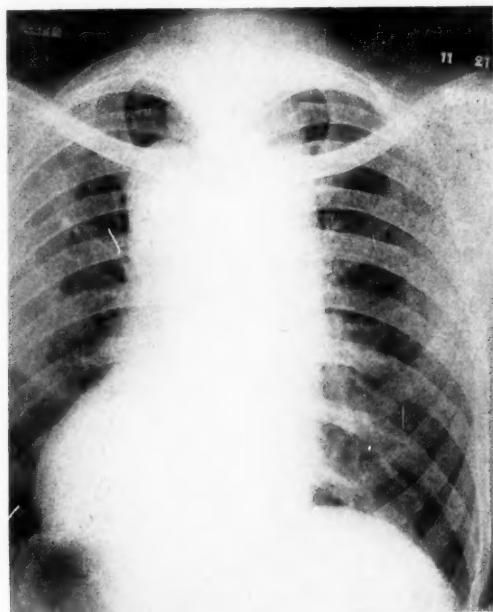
Case 251358. Aortitis. Clinical findings: Potain's sign; to-and-fro murmur, systolic predominance; aortic second sound clanging or reverberating; substernal pain. x-Ray shadow: Uniformly broadened.
